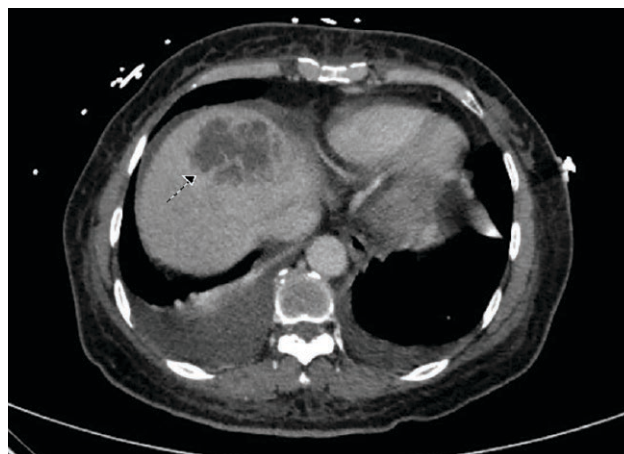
Computed tomography scan of the abdomen with intravenous contrast showing the abscess at the dome of the liver (arrow).
